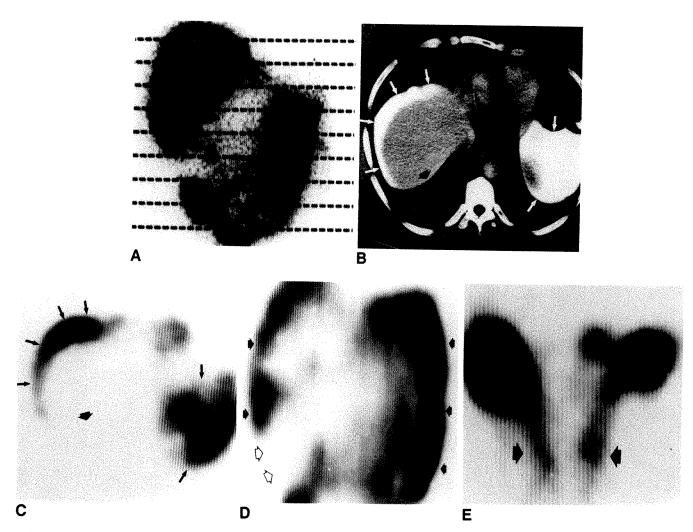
Examples of SPECT and CT correlative anatomy.
